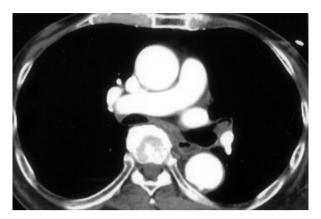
Sputum or a nodule in the left bronchus revealed by chest computed tomography
